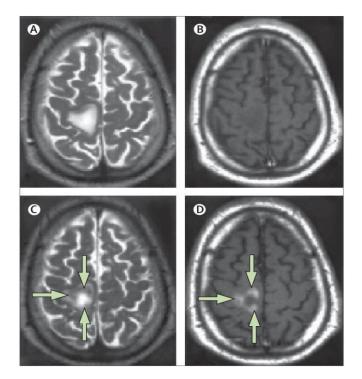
The lesion is hyperintense on the spin-echo T2-weighted image (A), but does not enhance with gadolinium on the T1-weighted image (B).
